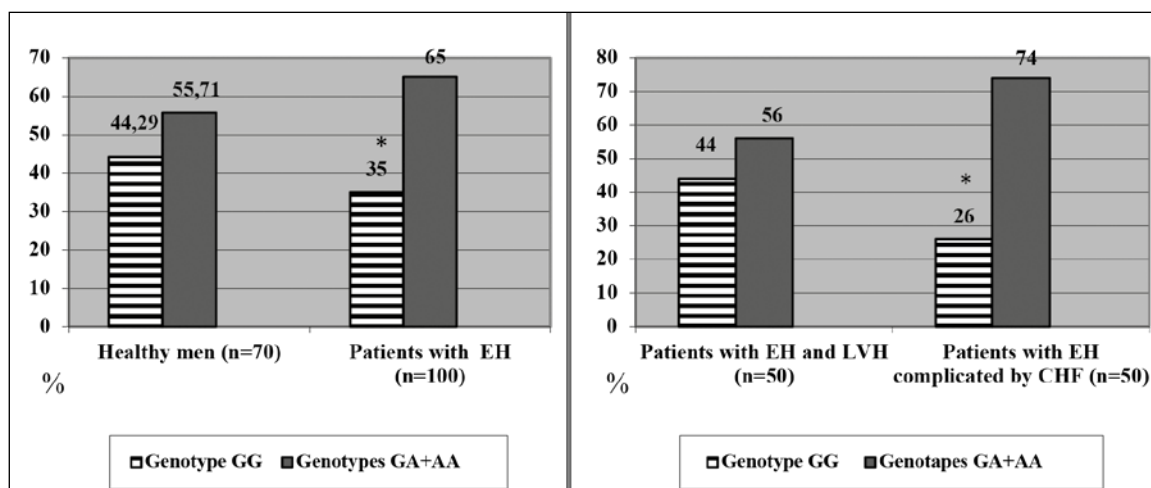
The distribution of the CT-1 gene genotypes frequencies in men citizens of Podillya region in the healthy patients and the patients with EH and LVH and EH complicated by CHF (%).
